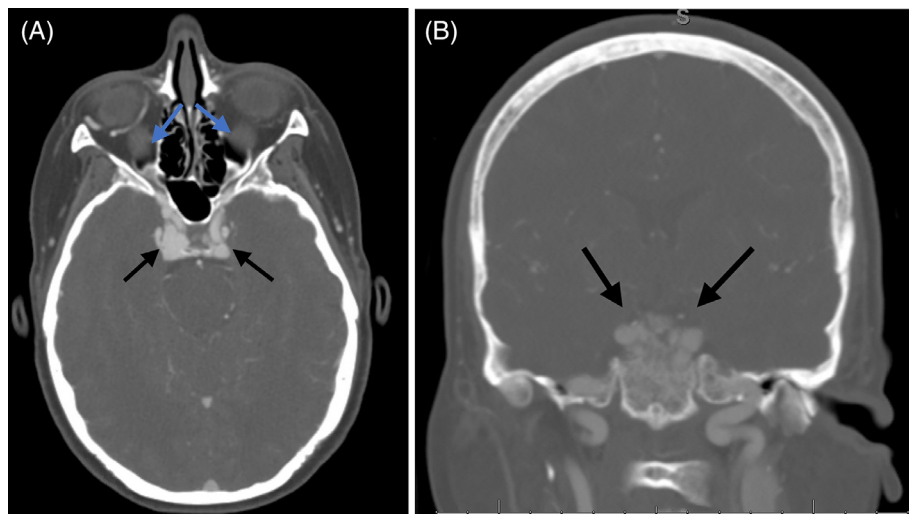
(A) Axial CT angiogram of the head showing opacification of the bilateral cavernous sinus (black arrows) and distention of the orbital veins (blue arrows). (B) Coronal CT angiogram of the head showing opacification of the bilateral cavernous sinus. Abbreviation: CT, computed tomography.
